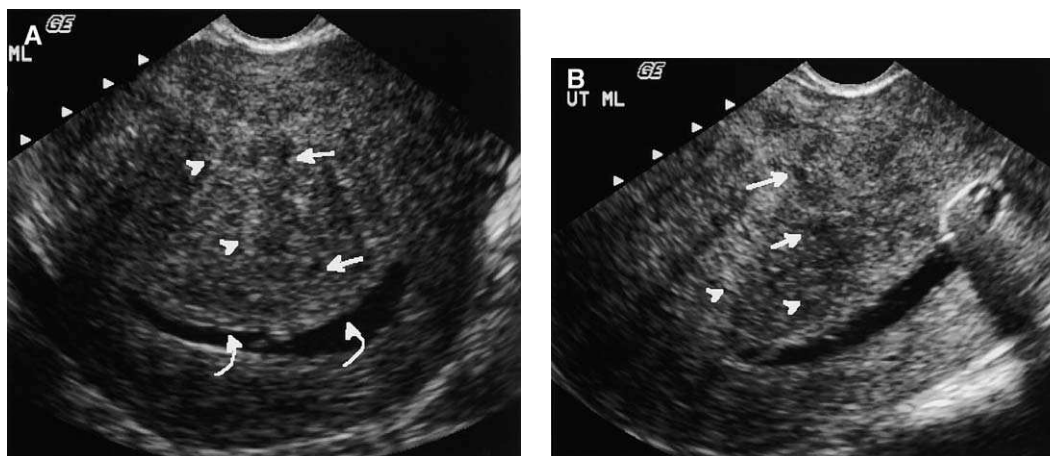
Coronal (A) and sagittal (B) SHG in a 36-year-old woman with heavy menses and suspected submucosal fibroid shows the classic sonographic findings of adenomyosis. Note the presence of myometrial cysts (arrows), myometrial echogenic nodules (arrowheads), and asymmetric anterior wall swelling causing a slight impression on the endometrial lining and cavity (curved arrows).
